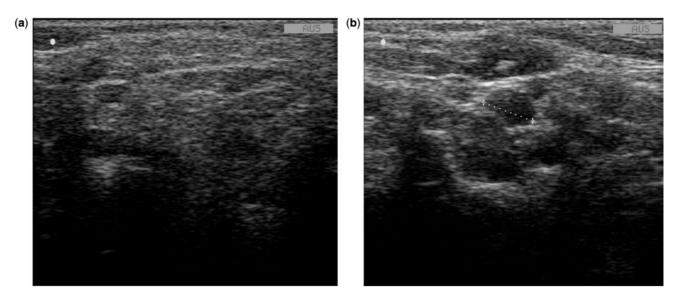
Sonography of a parotid gland in patients with pSS. (a) Gland with irregular echogenicity and multiple hyperechoic bands and hypoechoic areas (grade 3); (b) gland with irregular contour, multiple large hypoechoic areas and multiple cysts (>6 mm) resulting in severe damage of the parenchymal architecture (grade 4).
